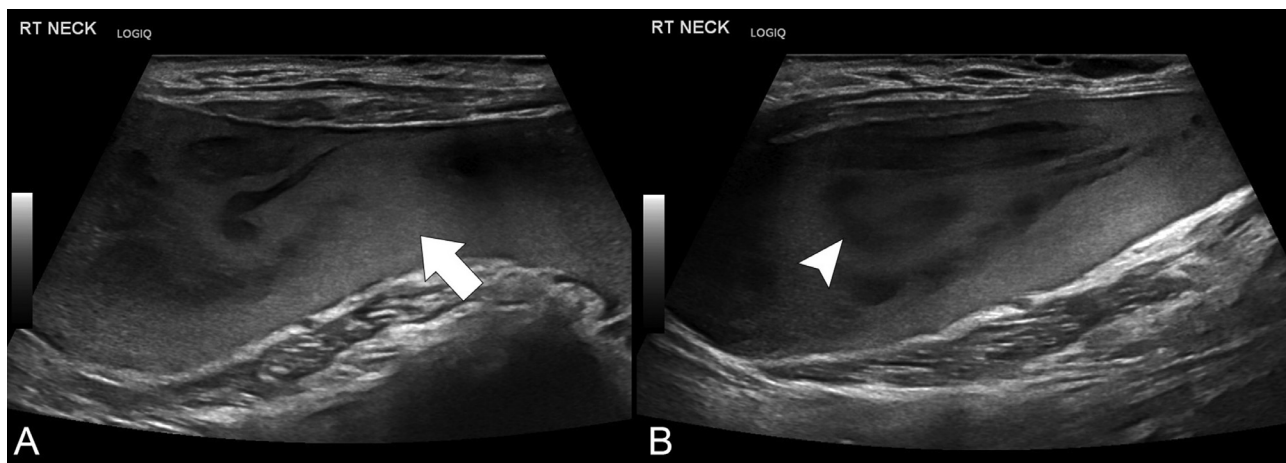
Greyscale ultrasound images of the right side of the neck showing (A) well-defined cystic lesion with fine internal echoes (arrow); (B) and curvilinear swirling mobile hypoechoicities (arrowhead).
